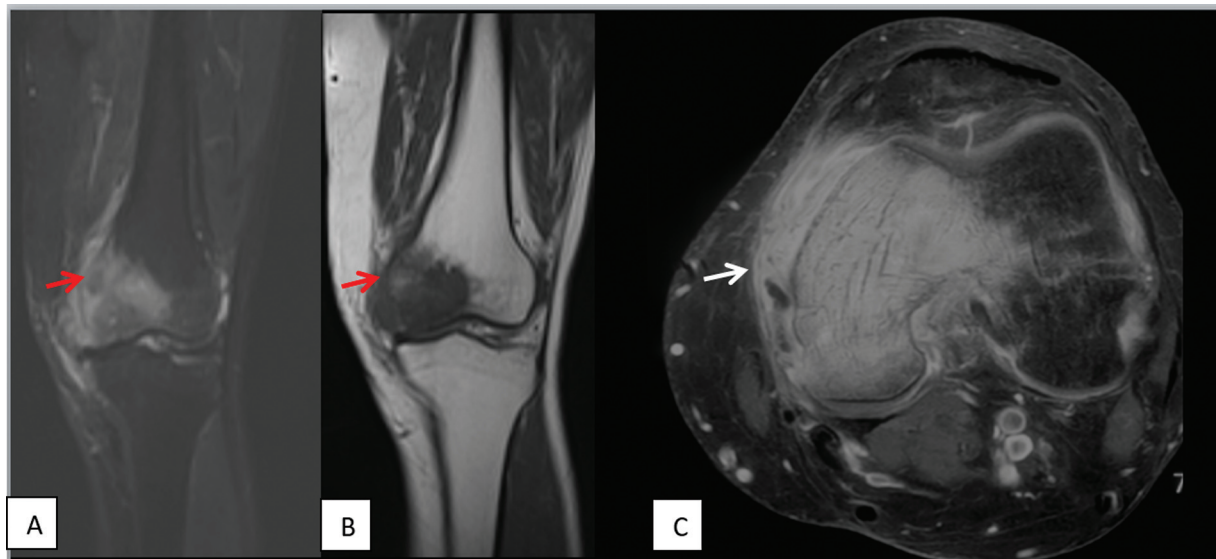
(A) Heterogeneous hyperintense lesion on short tau inversion recovery (STIR) coronal image (*red arrow*), (B) hypointense on T1 coronal image of magnetic resonance imaging (MRI; *red arrow*) involving the (C) left medial femoral condyle with adjacent soft tissue component showing enhancement (*white arrow*) on axial postcontrast T1 images.
